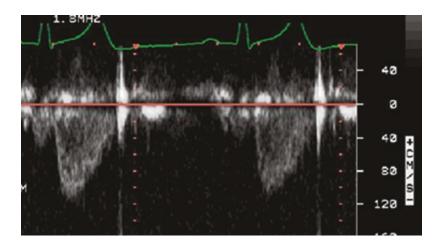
Pulsed wave Doppler spectral waveform with the baseline shifted higher so that the peak velocity is now seen
